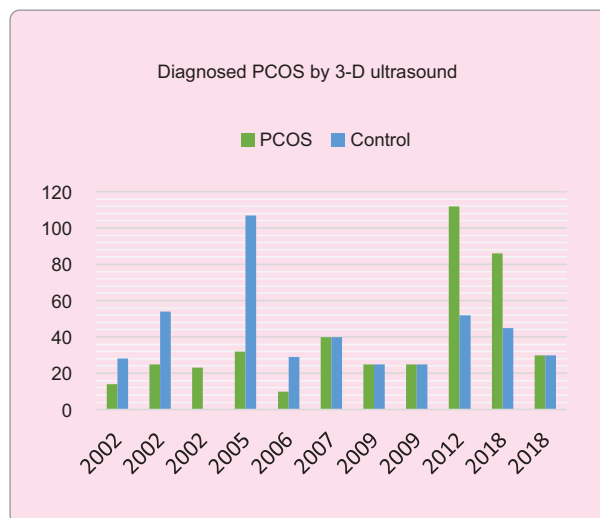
The eligible participants of PCOS patients versus control among eleven studies by 3-D ultrasound.
